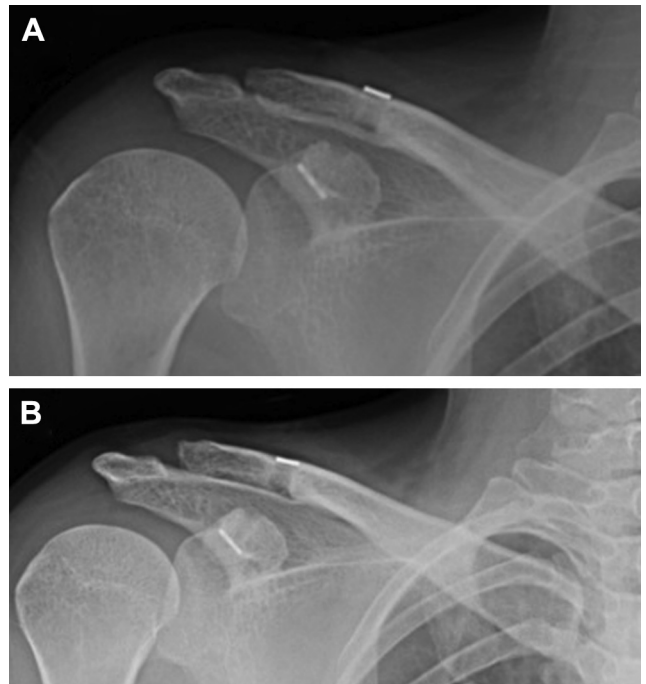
(A) Postoperative radiograph showing coracoclavicular (CC) reconstruction using a single adjustable—loop-length suspensory fixation device. The clavicular button is fixed on the superior surface of the clavicle. (B) Anteroposterior radiograph showed increased CC interval caused by superior cortical surface erosion of the clavicle by the clavicular button 6 months postoperatively.
